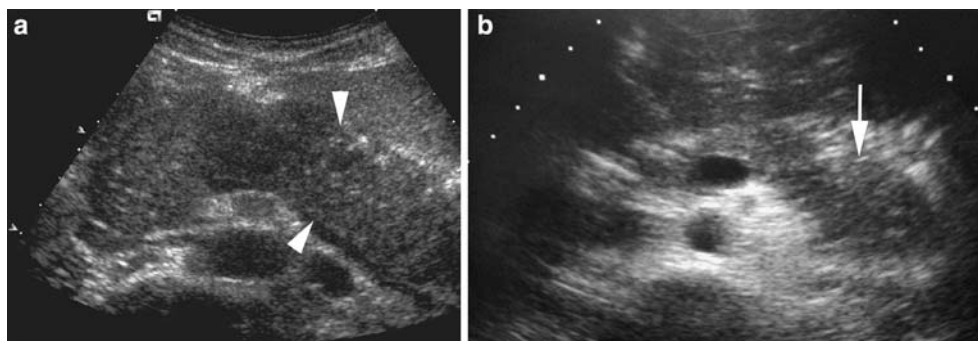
Autoimmune pancreatitis. A Diffuse form. At ultrasound the pancreas is diffusely hypoechoic and increased in volume (*arrowheads*), with a “sausage” appearance. The Wirsung duct is completely compressed and not visible. B Focal form. Focal enlargement of the pancreatic tail (*arrow*) in a 25-year-old male without other radiological signs.
